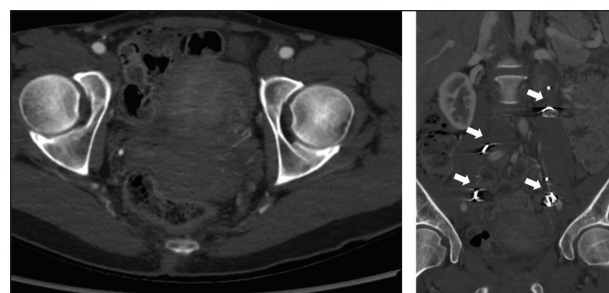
CT scan at 1-month follow-up for case 1 showing thrombosed ovarian veins bilaterally and no filling of pelvic varicosities. IMPEDE Embolization Plugs are denoted by arrows.
